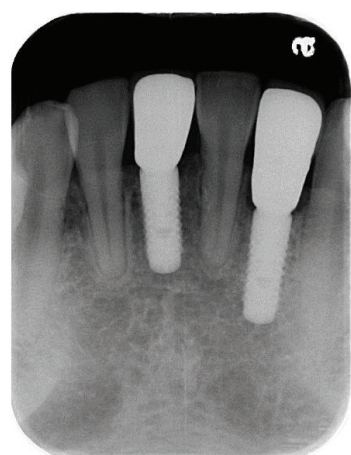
Radiographs after delivery of definitive crowns in mandibular anterior region.
